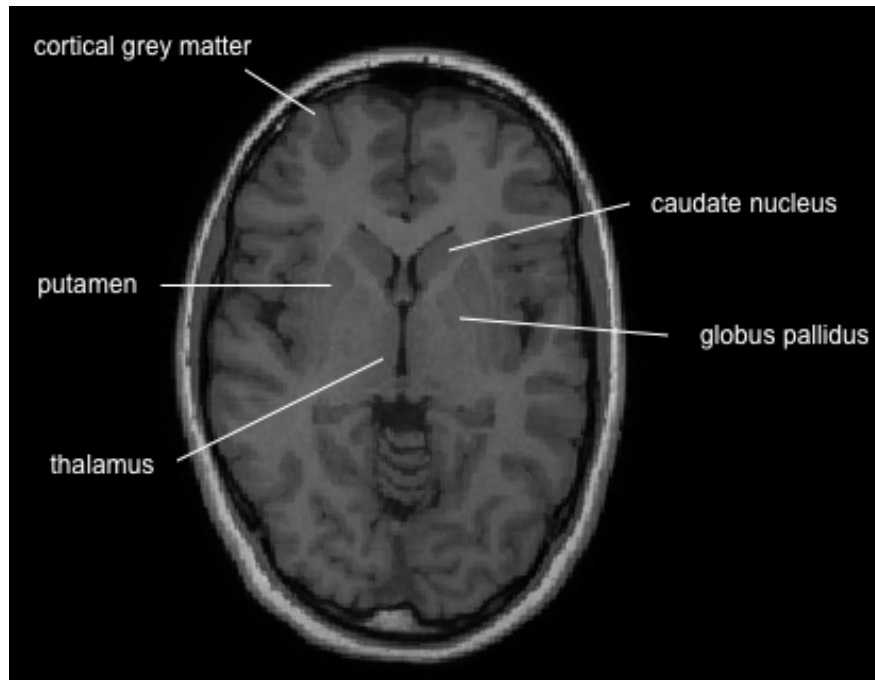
Grey matter anatomy. Axial T1-weighted MRI slice showing the grey matter of the basal ganglia (caudate, putamen, globus pallidus), thalamus, and the cerebral cortex. Grey matter appears hypointense to white matter on this T1-weighted image.
